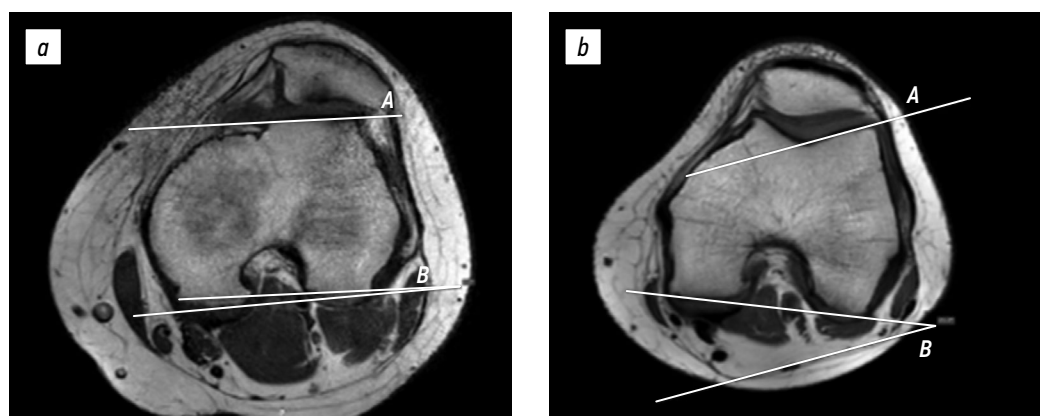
Lateral trochlear inclination on magnetic resonance imaging in a 15-year-old female patient with patellar instability (1.2°) (a) and in a 17-year-old female patient with anterior cruciate ligament injury (21°) (b). A, line tangent to the lateral facet; B, line tangent to the posterior condylar line.
